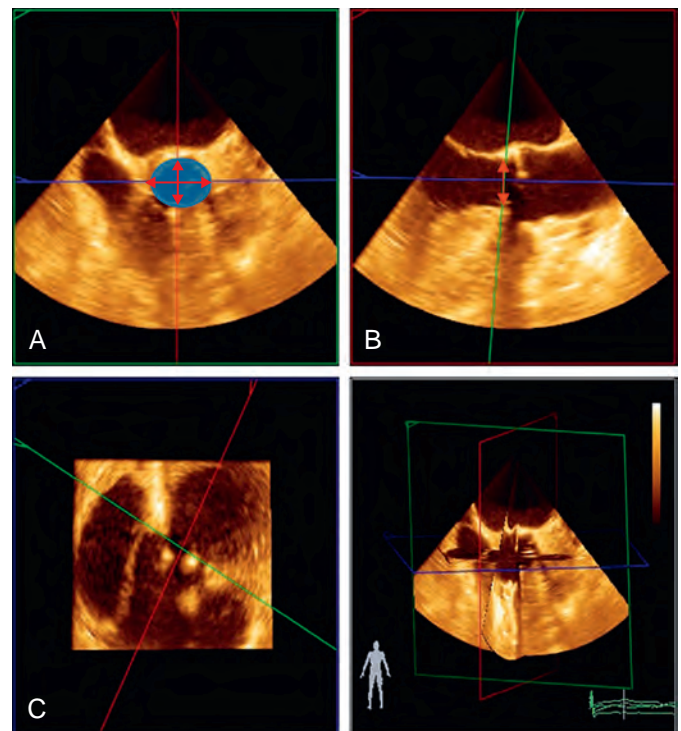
Multiplanar reconstruction from a real-time three-dimensional transesophageal echocardiography of the aortic valve showing (A) the transverse, (B) the sagittal, and (C) the coronal axes. Red arrows indicate the annulus measurement.
